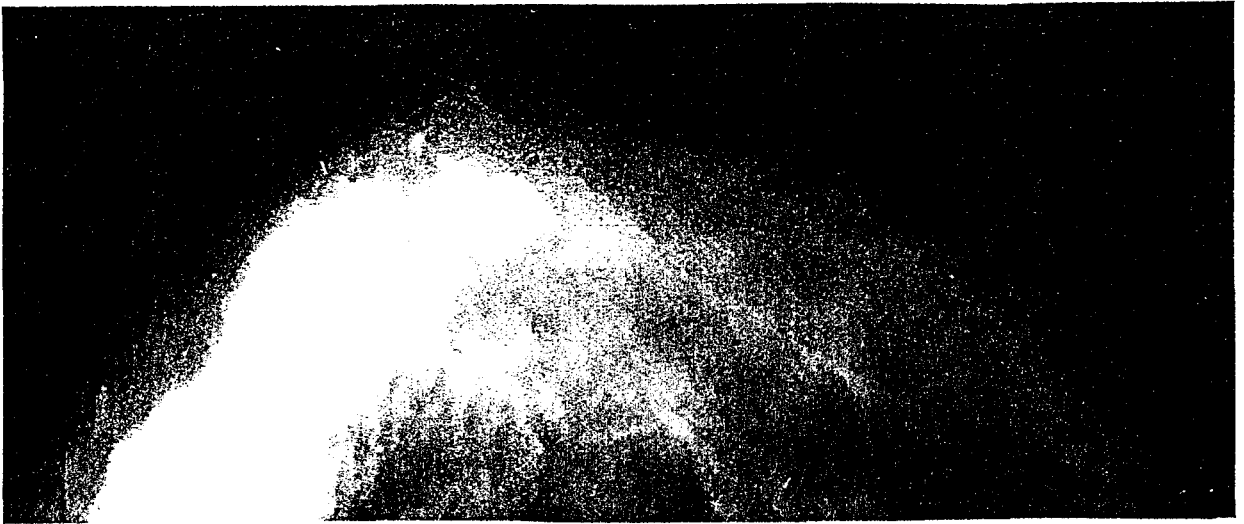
(a) Left breast, x-ray image.
